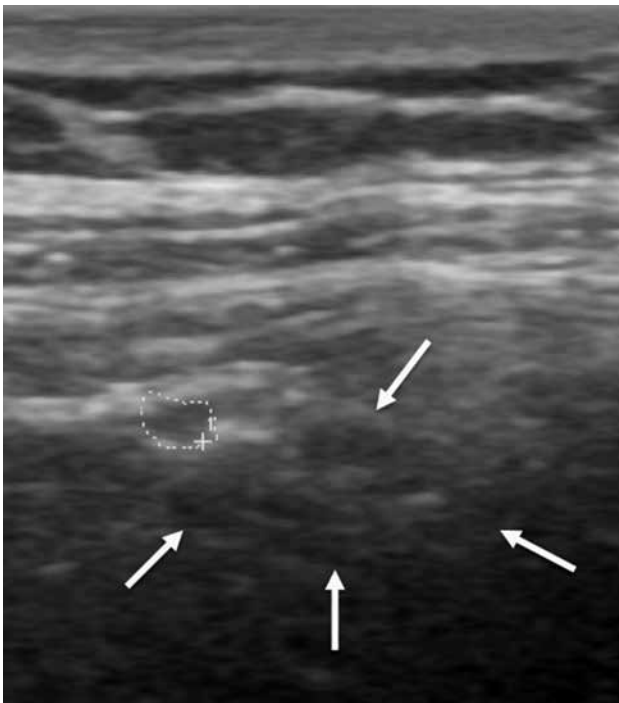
Longitudinal sonographic image demonstrating the lateral femoral cutaneous nerve (dashed line circle) and the inguinal lymphadenopathy (arrows).
